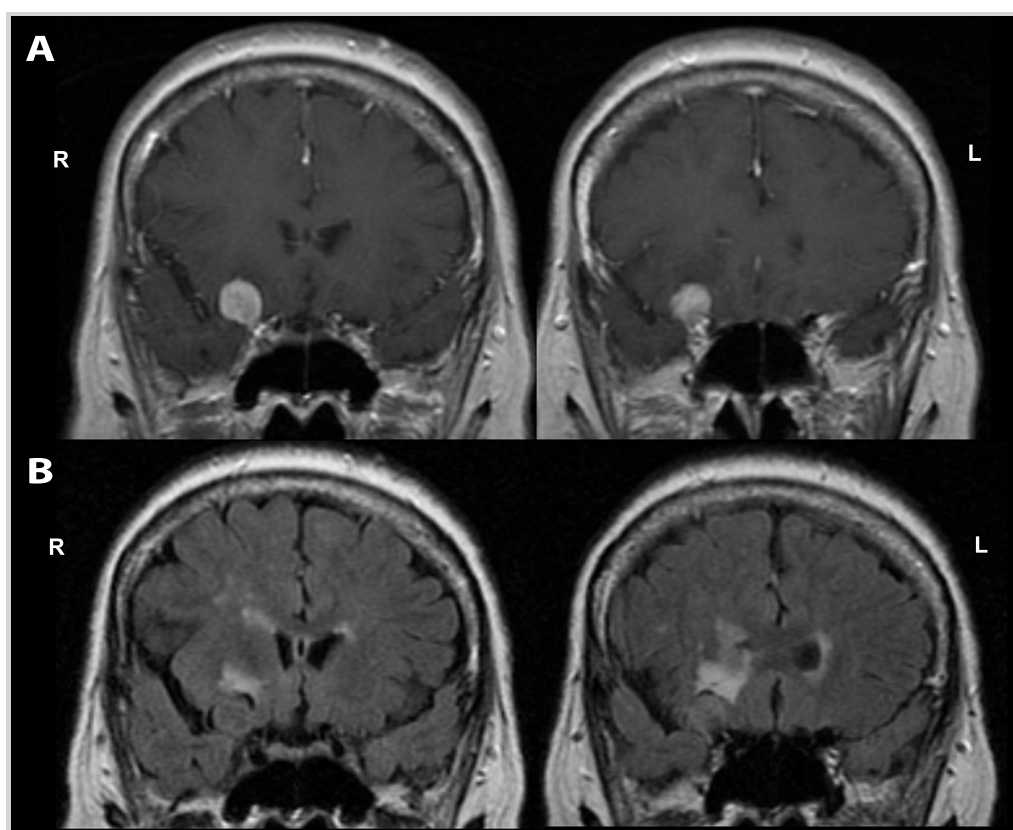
Brain MRI of the patient in Case 4-3. Coronal postcontrast T1-weighted (A) and noncontrast fluid-attenuated inversion recovery (FLAIR) (B) images show a dural-based enhancing extraaxial mass along the right anterior clinoid process, suggestive of a meningioma, with displacement of the right inferior frontal cortex, and surrounding vasogenic edema.
